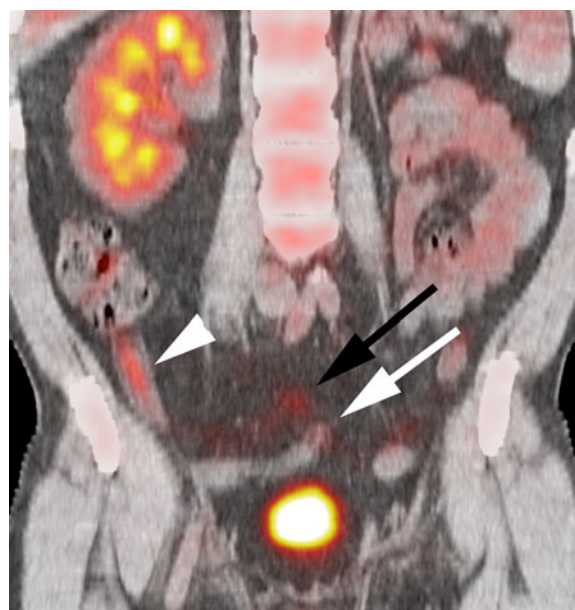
The PET image (A) and corresponding fused PET/CT image (B) from a patient with active Crohn's disease demonstrate an air- $^{18}\text{F}$ -FDG fluid level (black arrow) confirming physiologic intraluminal  $^{18}\text{F}$ -FDG activity, along with mural  $^{18}\text{F}$ -FDG uptake (white arrow) reflecting inflammation in the bowel wall.
